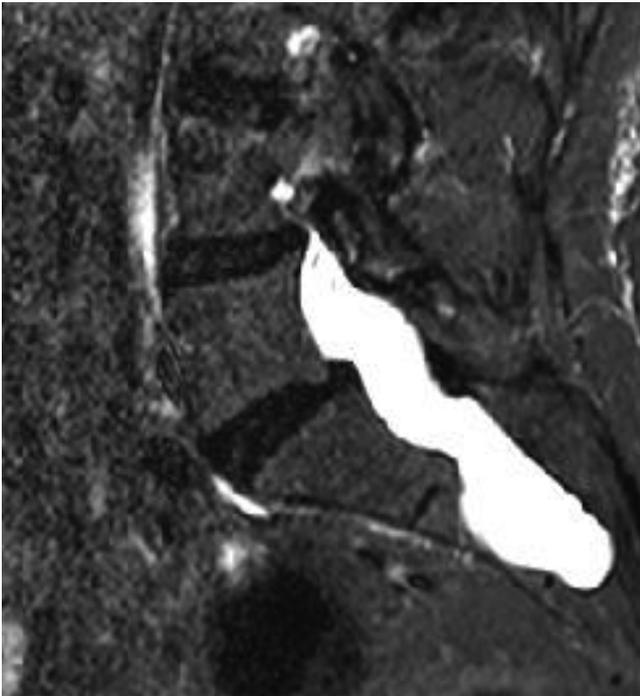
MRI showing L5-S1 discopathy and a classic sacral meningocele.
